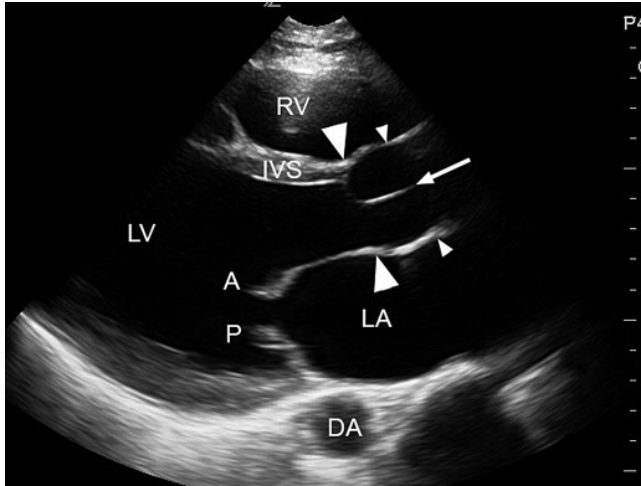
Demonstration of the parasternal long-axis view. The aortic annulus can be seen between the large arrowheads, as well as the apposed valve leaflets in diastole (arrow). Between the annulus and the sinotubular junction (small arrowheads) can be seen the sinuses of Valsalva. The left ventricle (LV), anterior and posterior mitral valve leaflets (A and P, respectively), left atrium (LA), right ventricle (RV), and descending aorta (DA) can be seen. Here, a right-sided pleural effusion can be seen adjacent to the DA. Figure © A. J. Dean.
